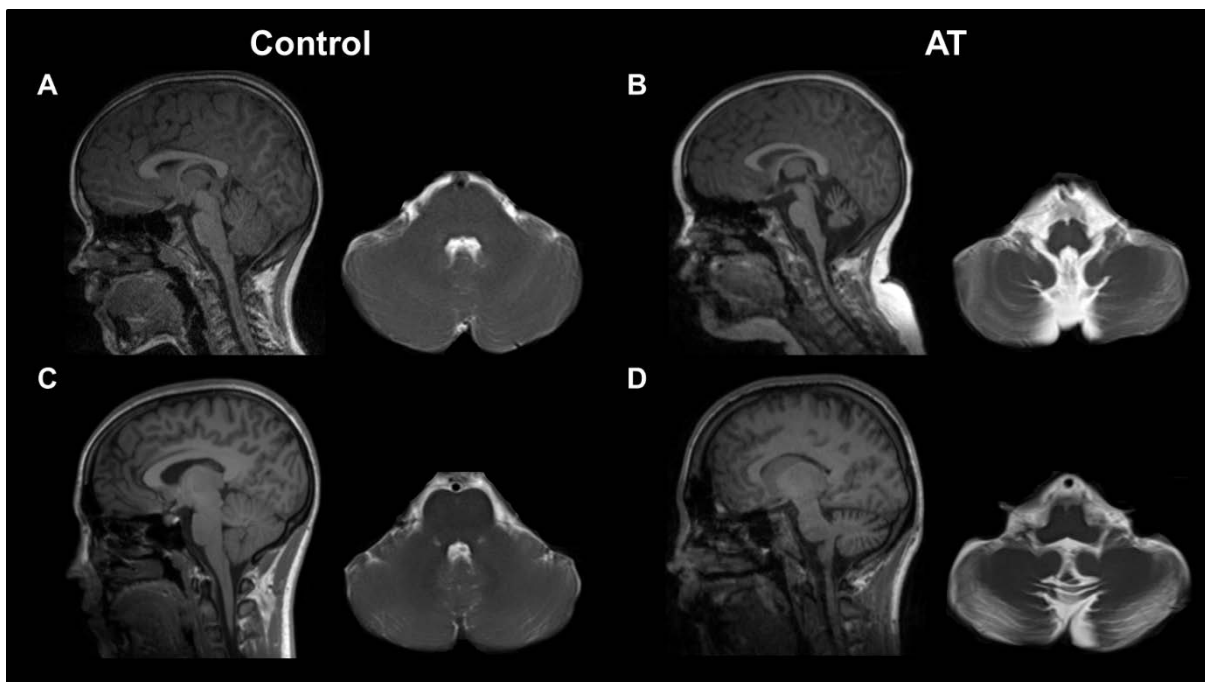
Age-matched sagittal T1 and axial T2 MRI scans acquired from control (A, C) and A-T patients (B, D). The representative images have been acquired from 7- (A, B) and 23-year-old
